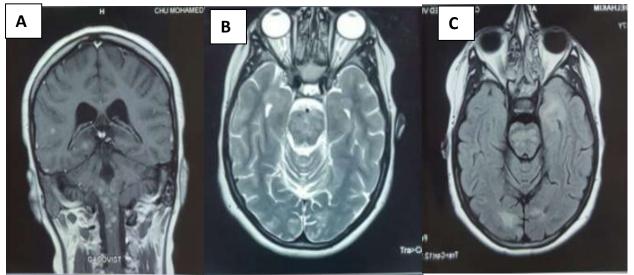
A: Coronal view T1-weighted MRI shows multiple nodular lesions in the brainstem. B-C: axial T2 and FLAIR MRI showing temporal, occipital and midbrain snowflake hypersignals.
